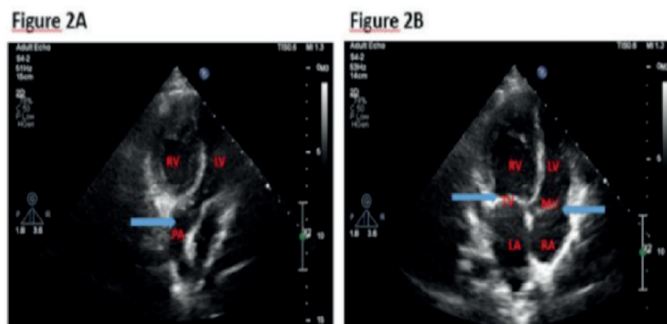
A: Apical four-chamber view demonstrating congenitally corrected transposition of the great arteries. RV, right ventricle; LV, left ventricle; PA, pulmonary artery; B: Modified apical transthoracic echocardiography view. RV, right ventricle; LV, left ventricle; TV, tricuspid valve; MV, mitral valve ; RA, right atrium ; LA, left atrium
